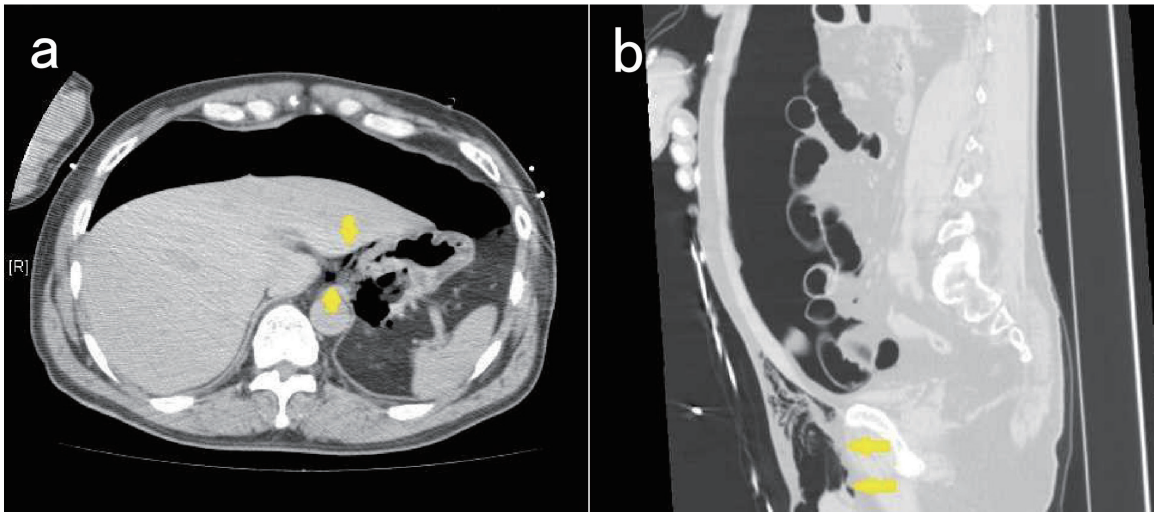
Computed tomographic image. a: A large amount of air was found in the abdominal cavity causing pneumoperitoneum. We also recognized a small amount of air in the lesser omentum (*arrows*). b: Subcutaneous emphysema was observed in the inguinal area (*arrows*).
